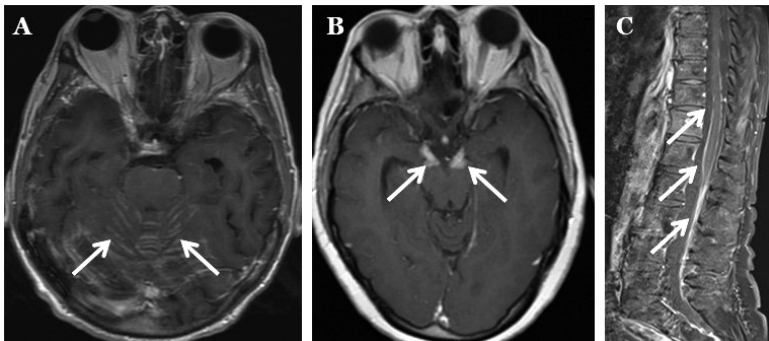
Axial images of post-contrast MRI scans showing leptomeningeal enhancement involving cerebellar folia (A), enhancement of the bilateral oculomotor nerves at the origins from the midbrain (B), and enhancement around spinal cord and the cauda equina (C).
